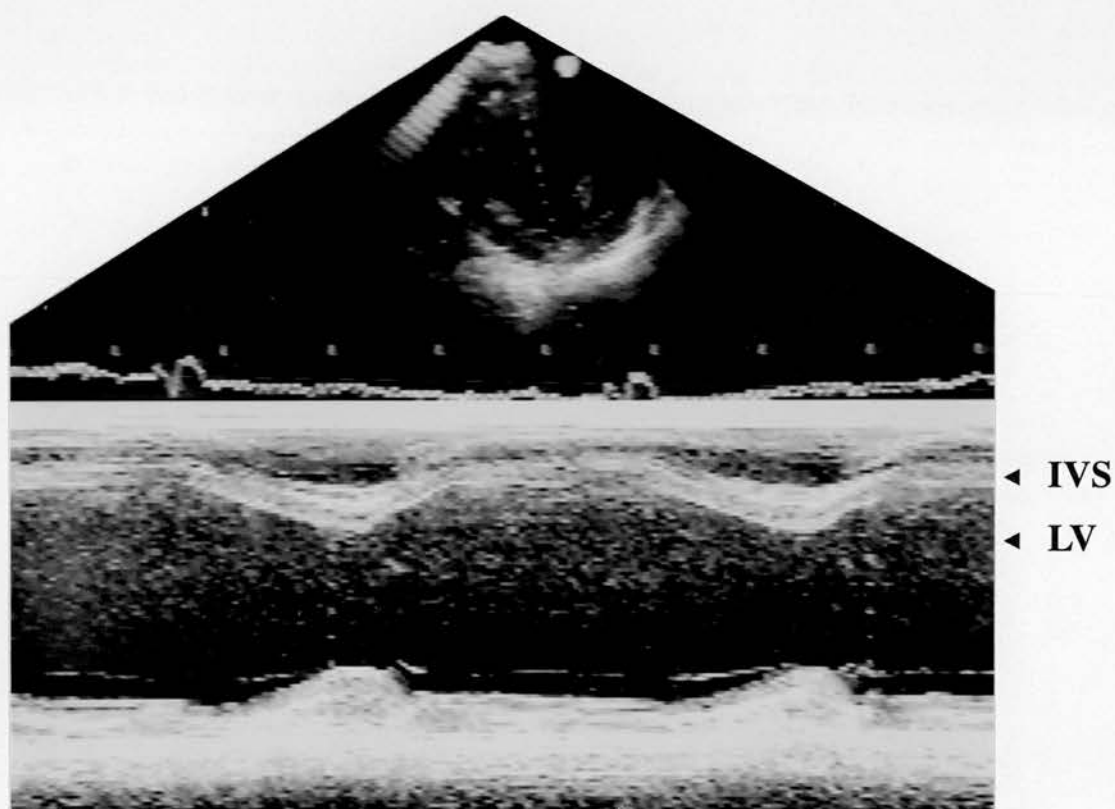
M-mode echocardiogram (short axis view) of a patient with borderline left ventricular dysfunction.
